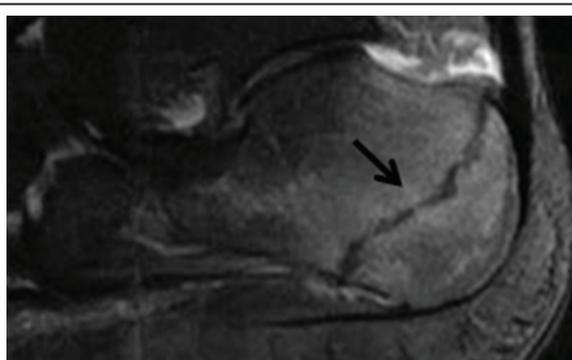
MRI, Healing stress fracture of calcaneum.
